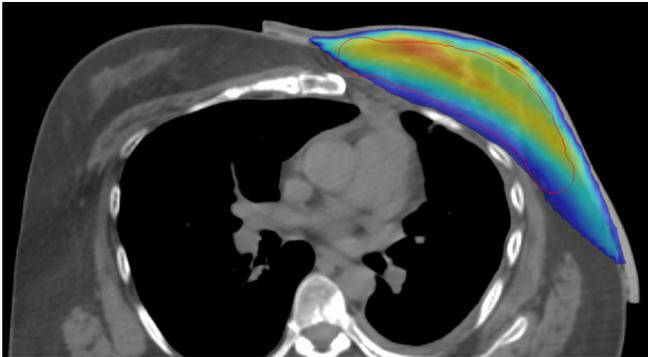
The treatment dose was verified in the TPS via a second CT scan prior to treatment.
